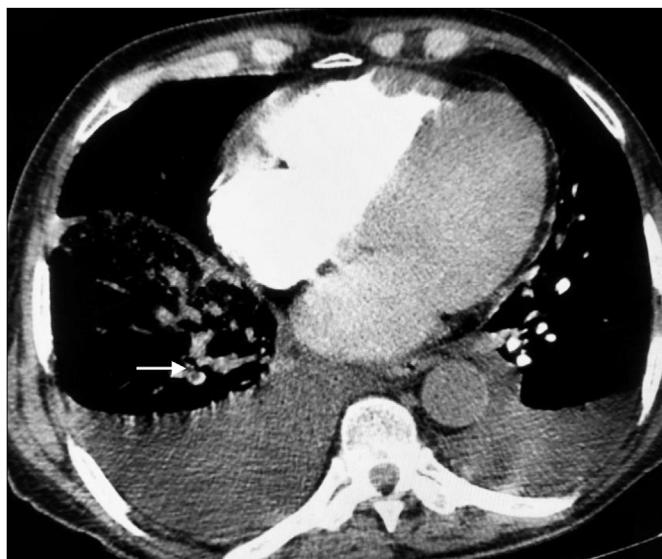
Pulmonary CT angiography shows pulmonary embolism in a right lower lobe segmental branch (arrow).
